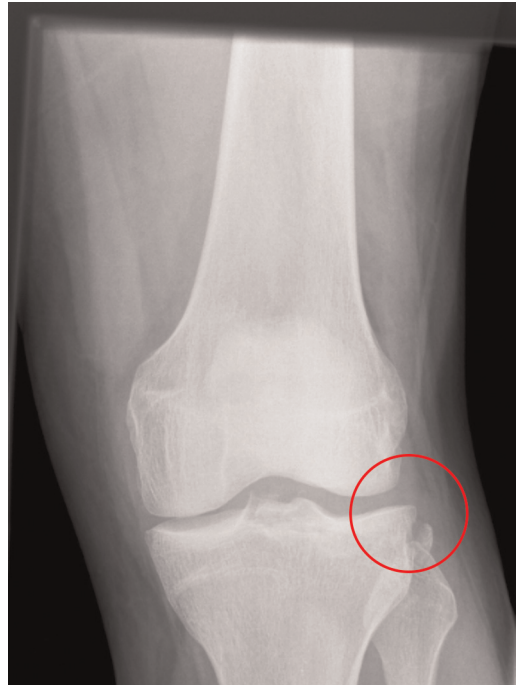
Radiograph of a Segond fracture.
